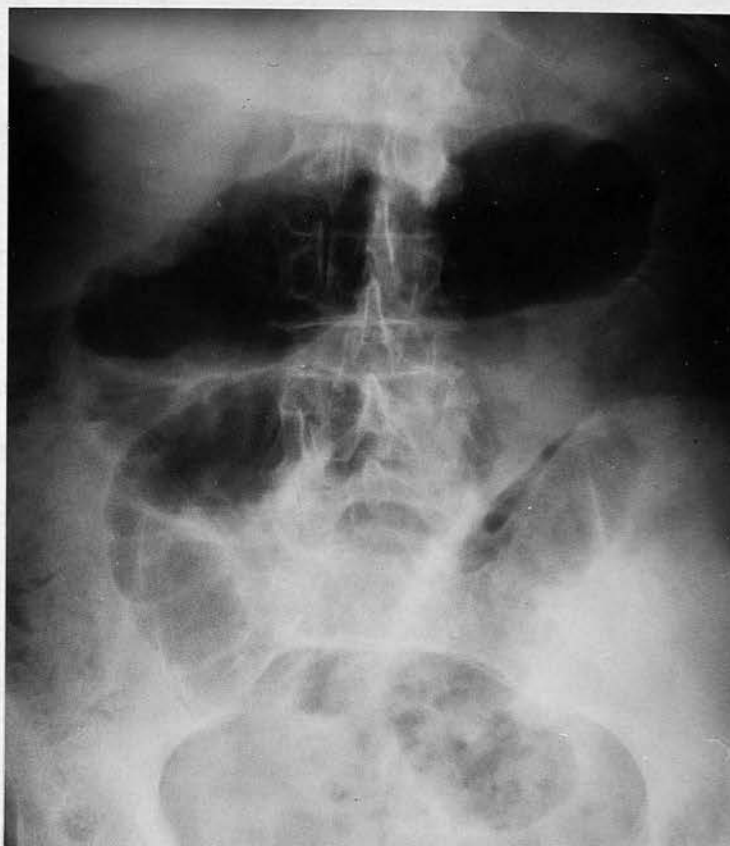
Plain abdominal X-ray showing moderately dilated loops of small bowel
